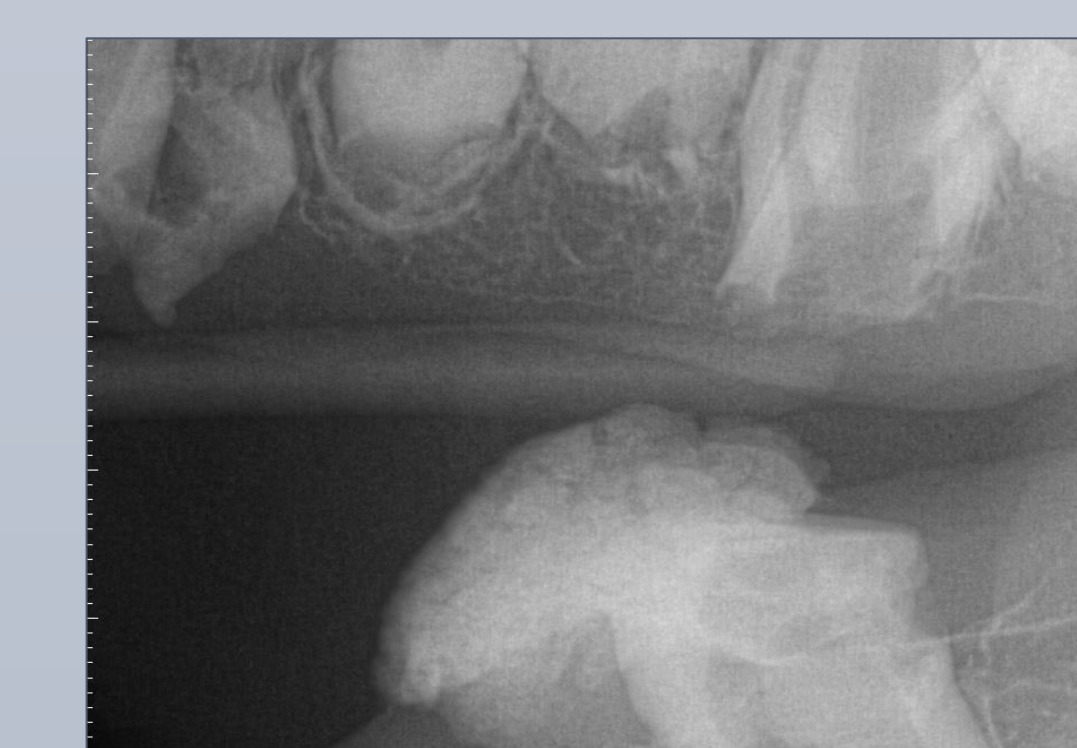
Left Bitewing 4/27/2022
